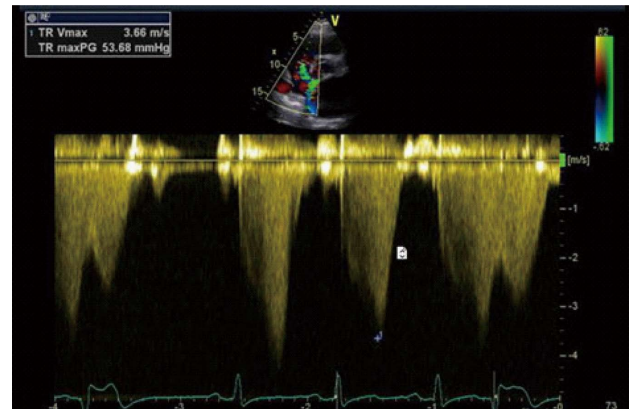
Continuous wave Doppler demonstrating blood flow velocity (3.66 m/c) across the tricuspid valve.
